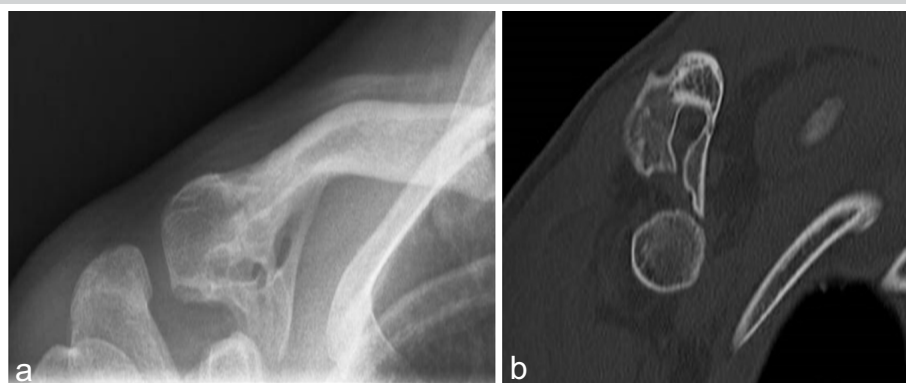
(a and b) Anterior-posterior view X-ray of the right shoulder and anterior-posterior of computed tomography scan screenshot through coracoclavicular ossification of case 2.
